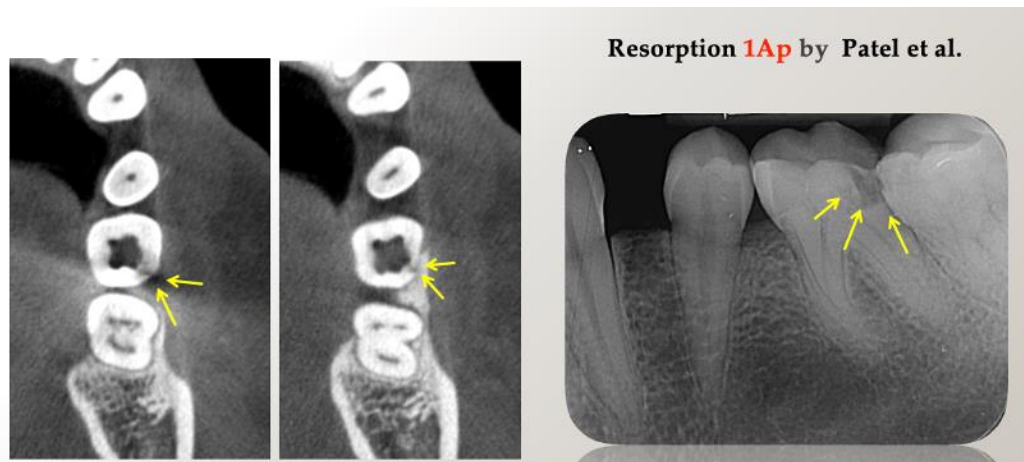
Case presentation - ICR on disto-buccal zone of tooth #36 - radiographic observation.
